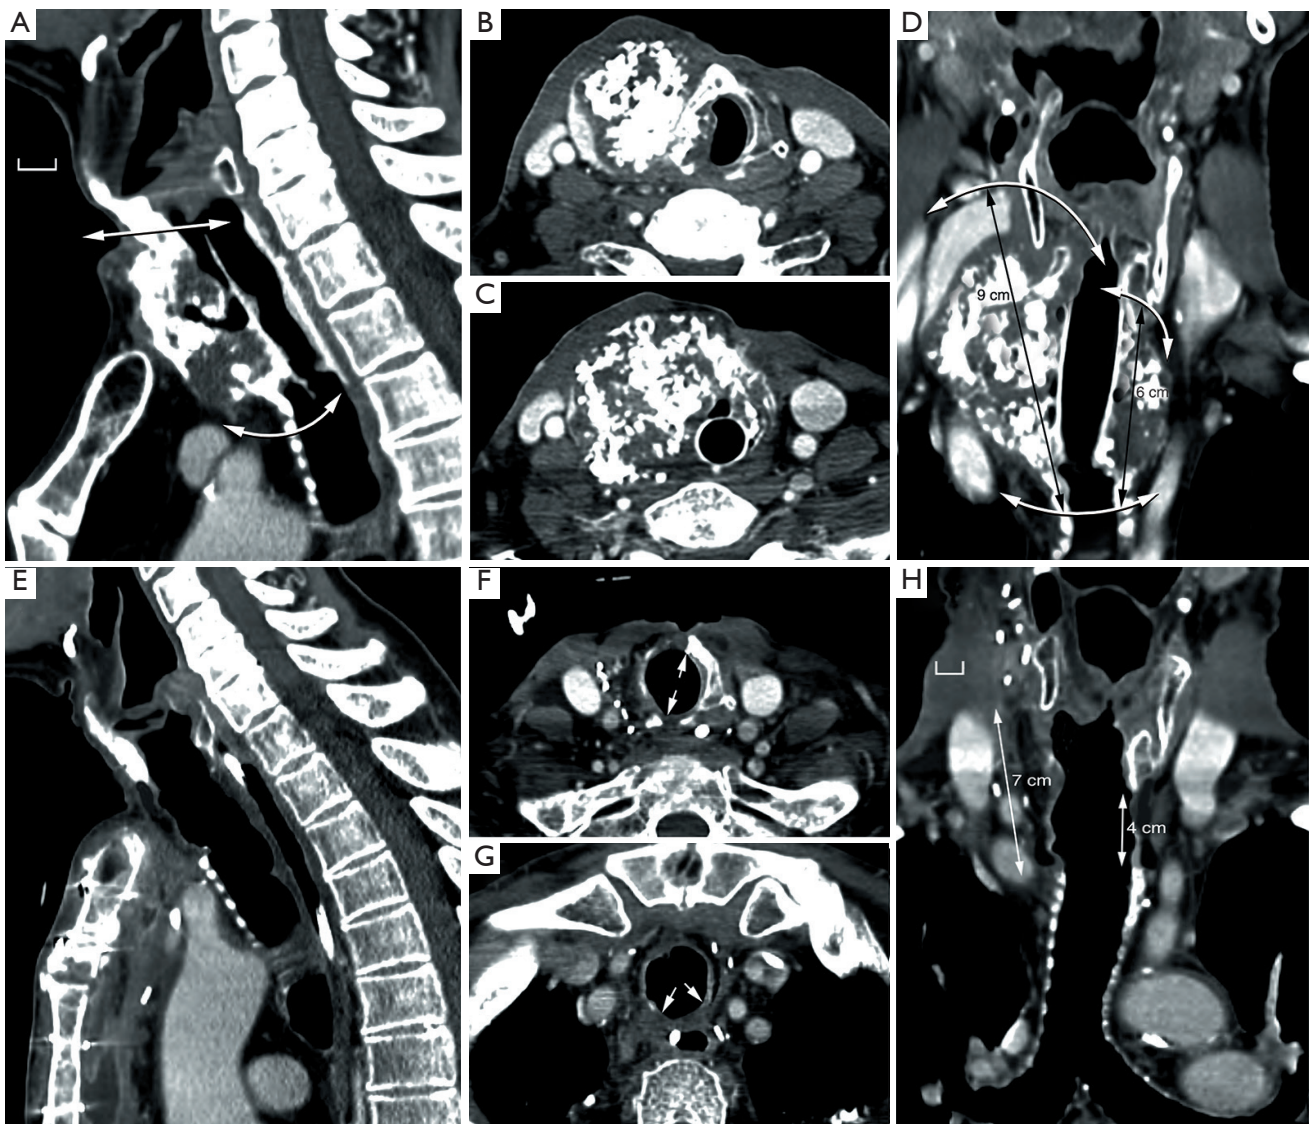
CT scan of tracheal chondrosarcoma before and after transplantation. Upper panel (A-D): before transplantation. Tumor extent is shown on sagittal (A), axial at subglottic (B), and tracheal (C) levels, and on coronal (D) section. Airway lumen is bridged by a silicone stent. Degree of resection is indicated with white two-headed arrows. Lengths of tracheal resection were 9 cm (right) and 6 cm (left) (scale: 1 cm). Lower panel (E-H): CT scans 2 years after orthotopic transplantation and 1 year after withdrawal of immunosuppressive drugs. Note the absence of cartilage calcification in the allotransplant (scale: 1 cm). (E) Sagittal reformatted CT scan. (F) Axial CT scan at laryngeal level. (G) Axial CT scan at level of cervical trachea. (H) Coronal reformatted CT scan. CT, computed tomography.
